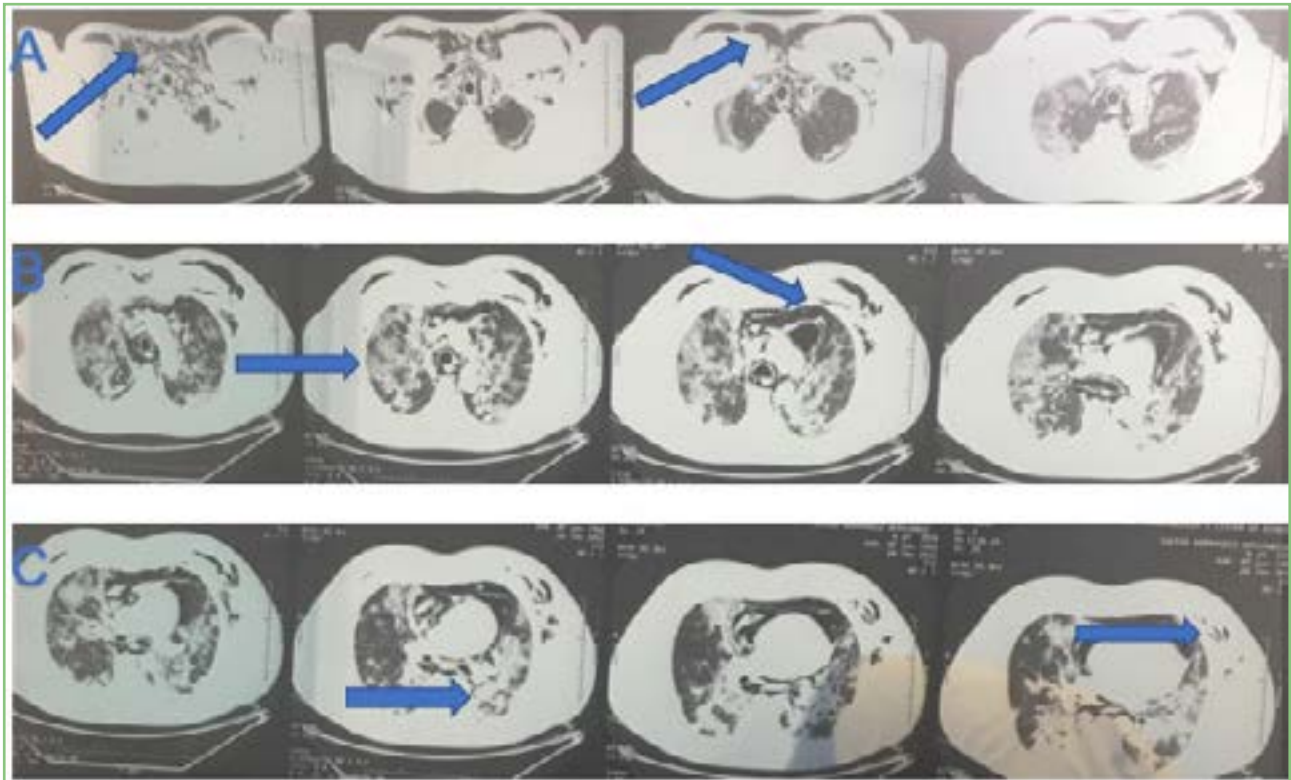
JHH. Computed Axial Tomography of the chest at 20 days post-covid which shows pneumomediastinum, subcutaneous emphysema and consolidation B: Chest CT showing the magnitude of pneumomediastinum and subcutaneous emphysema C: Chest CT with consolidation and pneumomediastinum.
